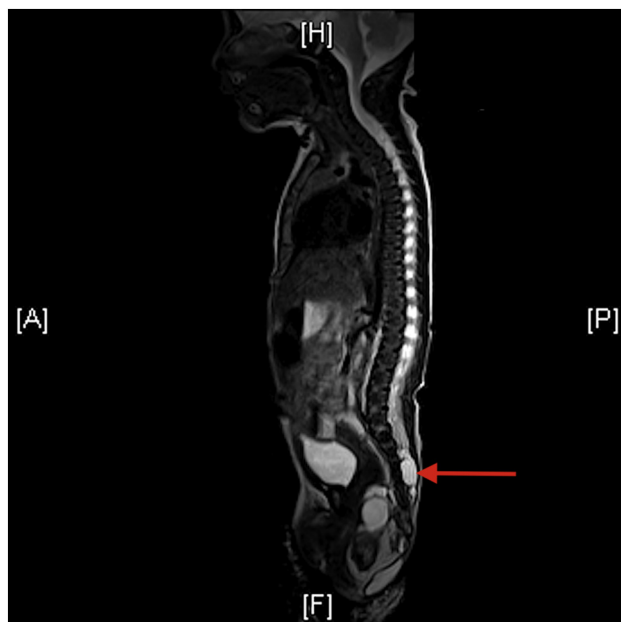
Preoperative sagittal T2-weighted MRI with intraspinal extension marked (red arrow). A = anterior, P = posterior, H = head, F = foot.
